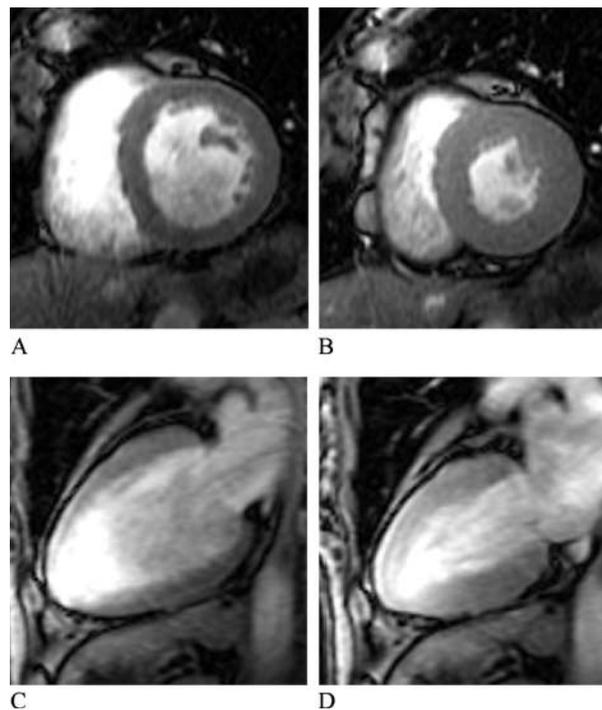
Breath-hold cine MR images of the left ventricle acquired with SPGR sequence in a patient with angina pectoris (the same patient in Fig. 1). A, Short-axis image at end-diastole; B, short-axis image at end-systole; C, long-axis image at end-diastole; D, long-axis image at end-systole.
